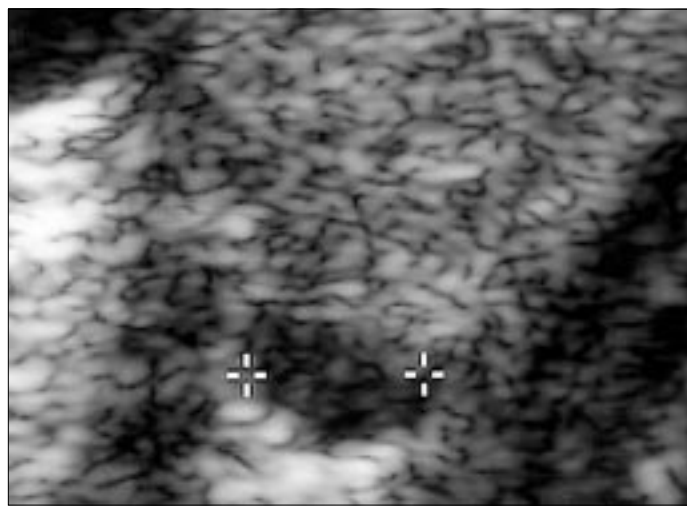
Ultrasound image shows a right superior parathyroid mass (calipers), 8 mm in maximum dimension. A similar right inferior parathyroid mass was present.
